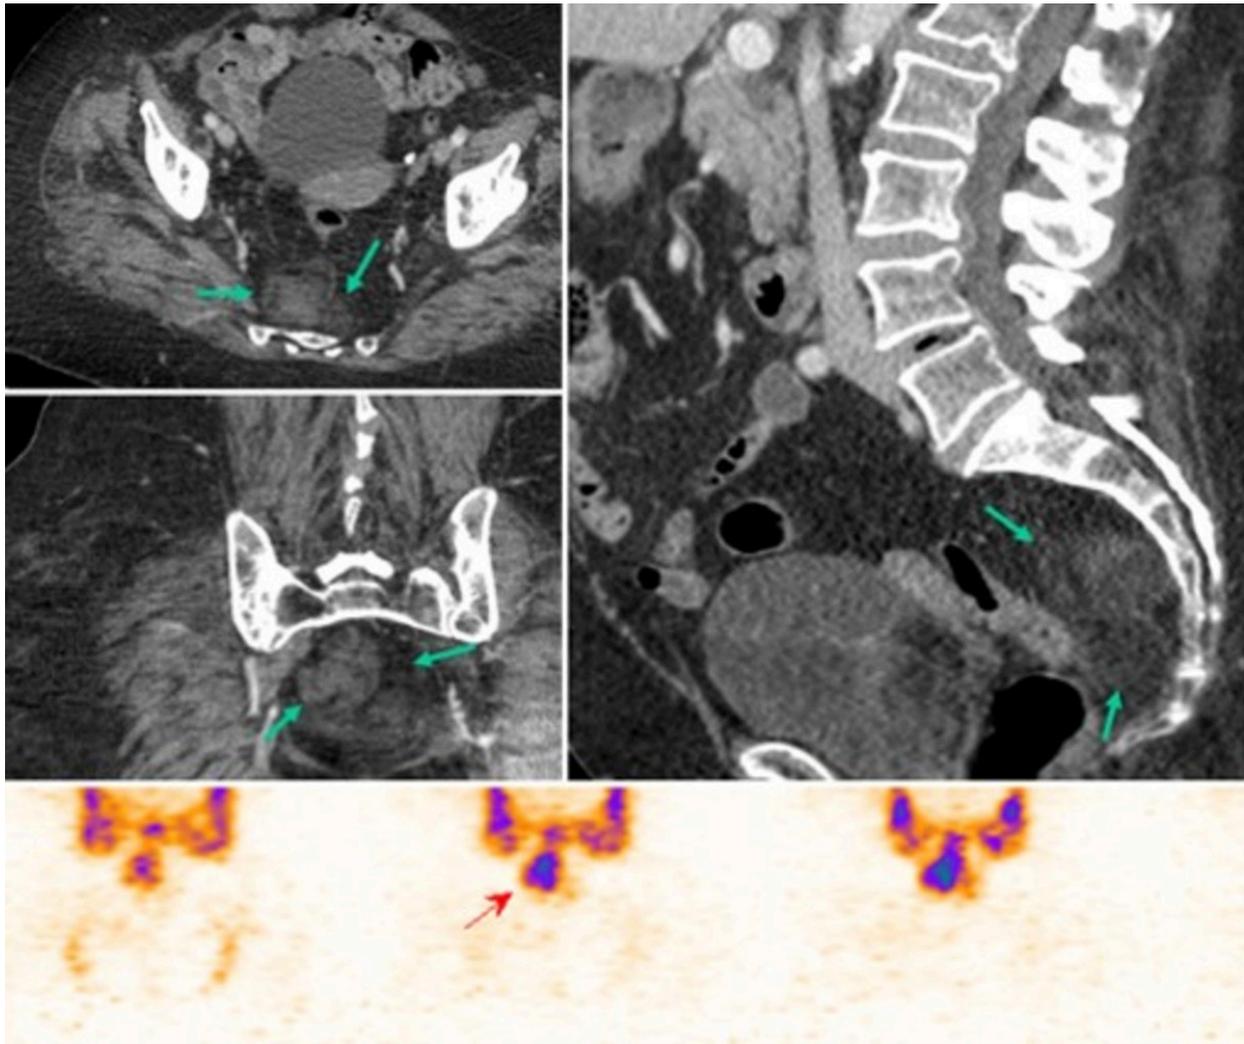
Axial, coronal and sagittal images show incidental lobulated, heterogeneous presacral mass without evidence of erosion/invasion of the anterior sacrum (arrows). The mass is composed of fat and soft tissue elements. In bone marrow scintigraphy, a pathologic, focally increased site of uptake is exhibited in the presacral region. This finding was helpful to differentiate the lesion (arrows) from other lipid containing soft tissue tumors, thus supporting the initial diagnosis of myelolipoma.
